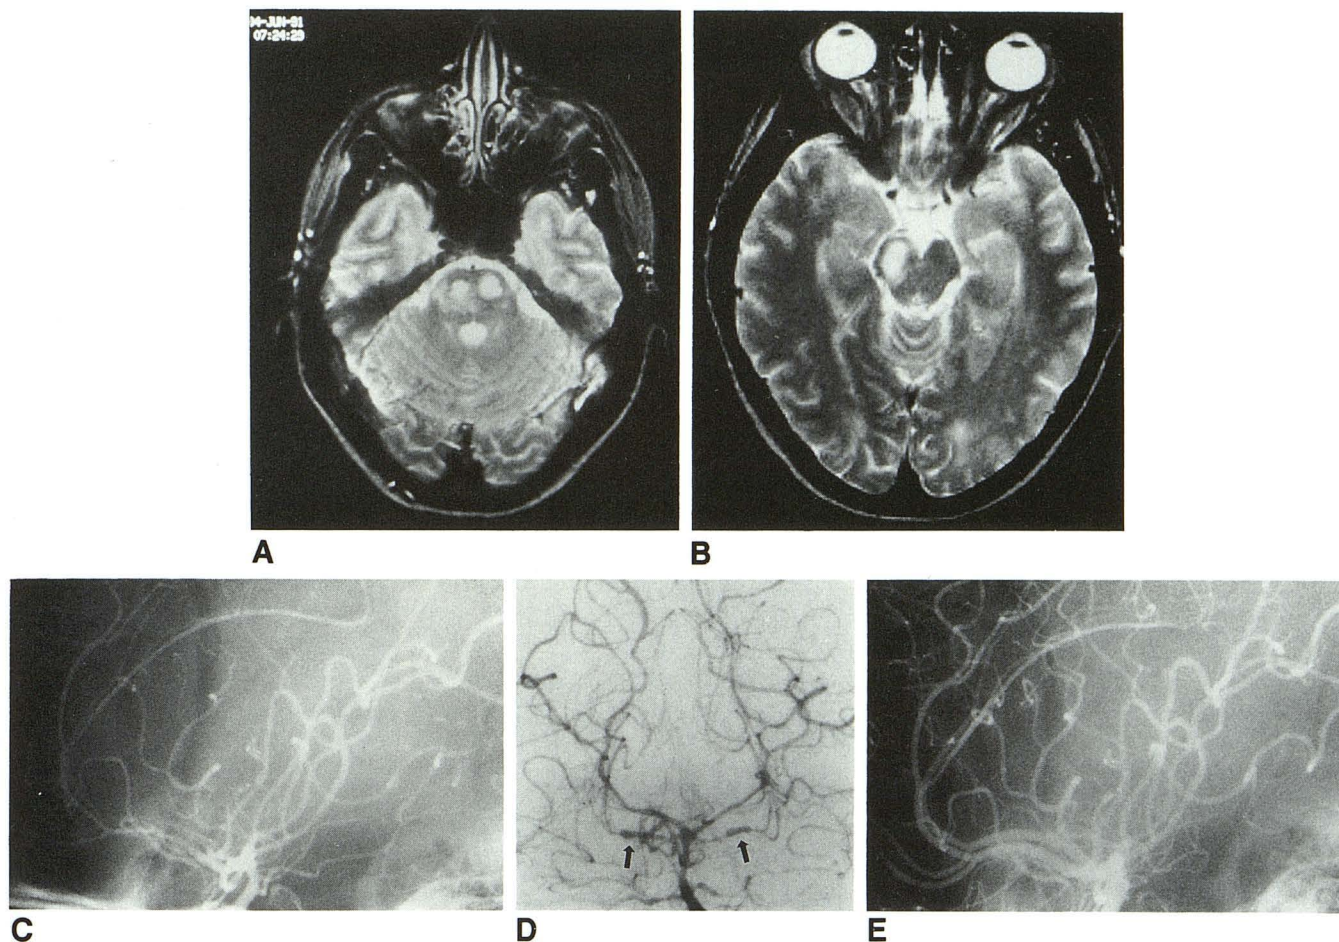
Patient 3: PACNS. This 28-year-old woman who was several weeks postpartum presented with headache and left hemiparesis. A and B, Axial T2-weighted MR images show hyperintensity within basis pontis, extending into right cerebral peduncle. There was intense enhancement in the pons with intravenous gadopentetate dimeglumine enhancement (not shown).
